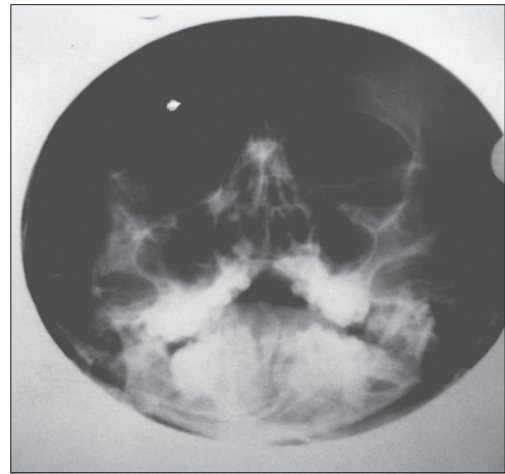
Water's view X-ray revealing malar hypoplasia on the left side of the face
